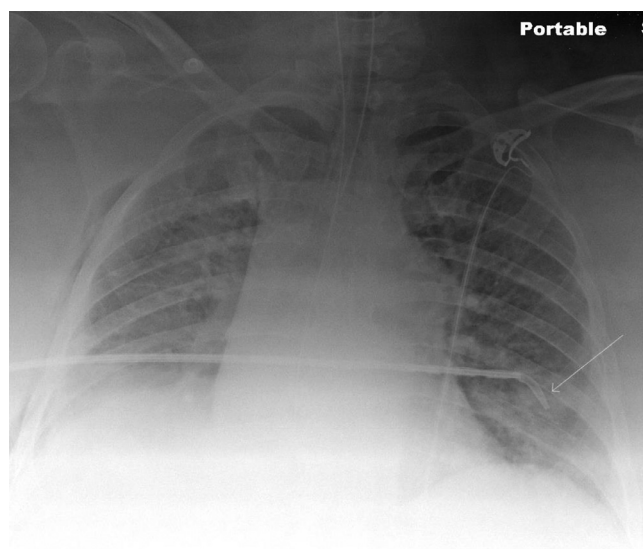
Chest x-ray after chest tube placement shows both chest tube and trocar traversing the heart.
